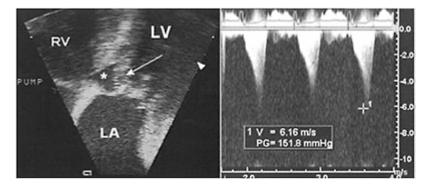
Severe hypertrophic cardiomyopathy with systolic anterior motion (SAM) of the mitral valve (arrow) into the left ventricular outflow tract (*). Continuous-wave Doppler (right panel) shows severe outflow tract obstruction, with a calculated peak gradient of 151 mmHg. Note that the late peaking is 'dagger-shaped'. RV: right ventricle; LV: left ventricle;
